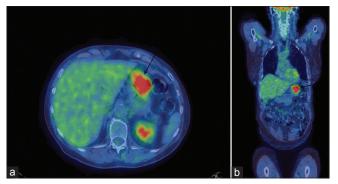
Axial (a) and coronal (b) 18F- FDG PET/CT scan showing significant 18-FDG uptake within the gastric mass
